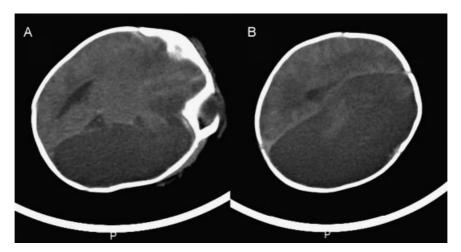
(A, B) Axial computed tomogram image showing diffuse hypodensity of left hemisphere except the territory of anterior choroidal artery and anterior cerebral artery, including basal ganglia, consistent with acute cerebral infarct. Also, cephalhematoma is seen over the left parietal area.
